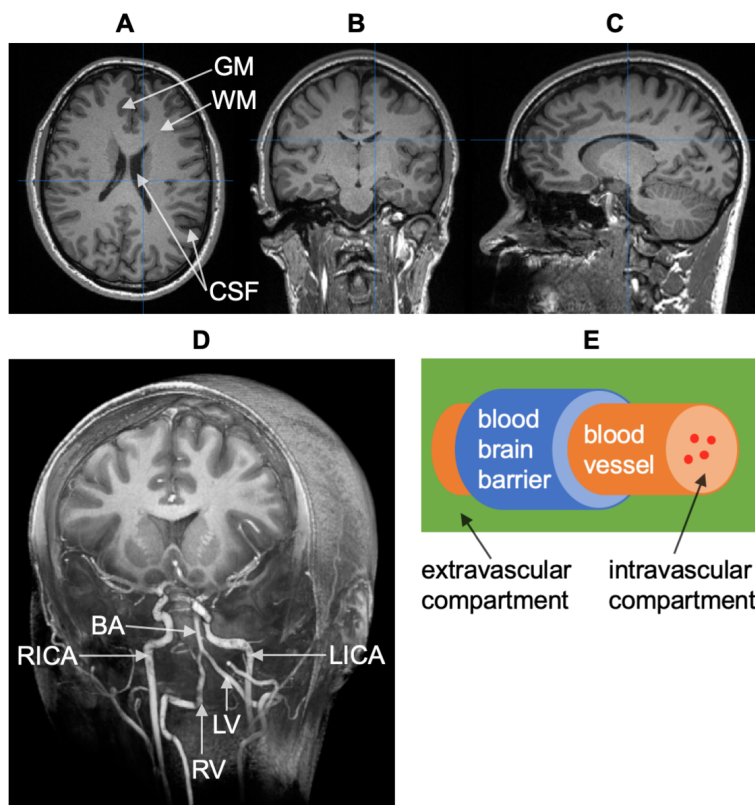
Overview of the human brain anatomy. (A-D) Structural  $T_1$ -weighted MP2RAGE 7 T MRI scan in (A) axial/transversal, (B) coronal/frontal and (C) sagittal/lateral 2D view as well as (D) a 3D rendering with annotated main blood supplying arteries: left/right internal carotid arteries (LICA/RICA), left/right vertebral arteries (LV/RV) and basilar artery (BA). In this image contrast white matter (WM) appears light, gray matter (GM) darker and cerebrospinal fluid (CSF) the darkest. The blue lines mark the slices of the 2D images. (E) A highly simplified representation of the blood-brain barrier, forming a boundary between the intravascular blood system and the surrounding extravascular tissue space.
